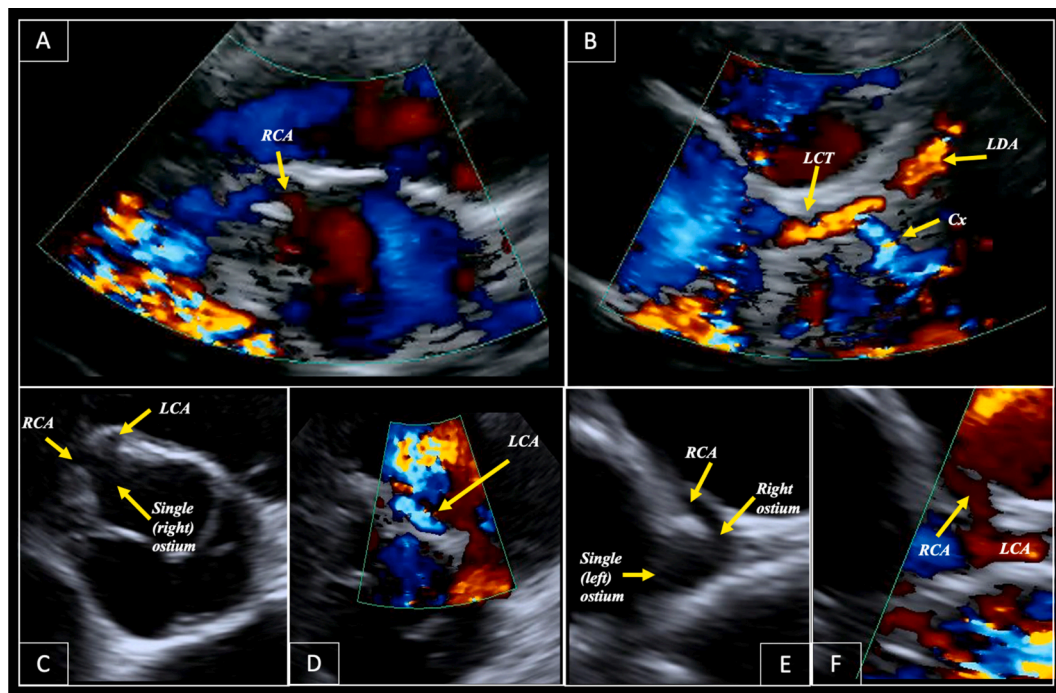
Evaluation of coronary artery by transthoracic echocardiography. Panel A: the right coronary artery (RCA) ostium and first tract are visualized arising from the right coronary sinus of Valsalva. The left coronary trunk (LCT), left descending artery (LDA) and circumflex artery (Cx) are nicely depicted in Panel B. Panel C shows the anomalous aortic origin of the left coronary artery: both the left coronary artery (LCA) and the right coronary artery (RCA) originate from a common right ostium in the right coronary sinus. The use of color Doppler clearly identify the interarterial intramural course of the LCA in Panel D. Panel E shows the anomalous aortic origin of the RCA from the left coronary sinus and the interatrial course of the RCA (Panel F).
